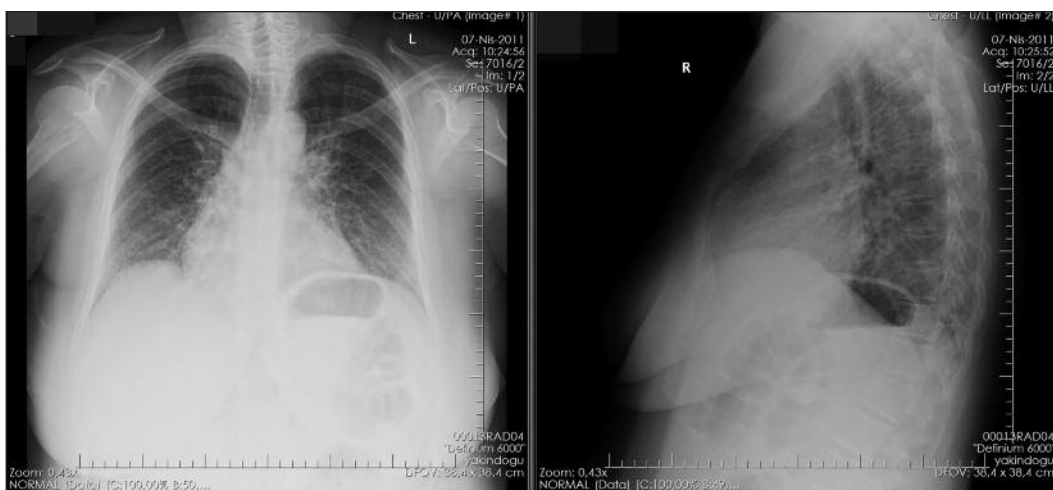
Chest X-ray revealed bilateral diffuse reticular infiltrations.
